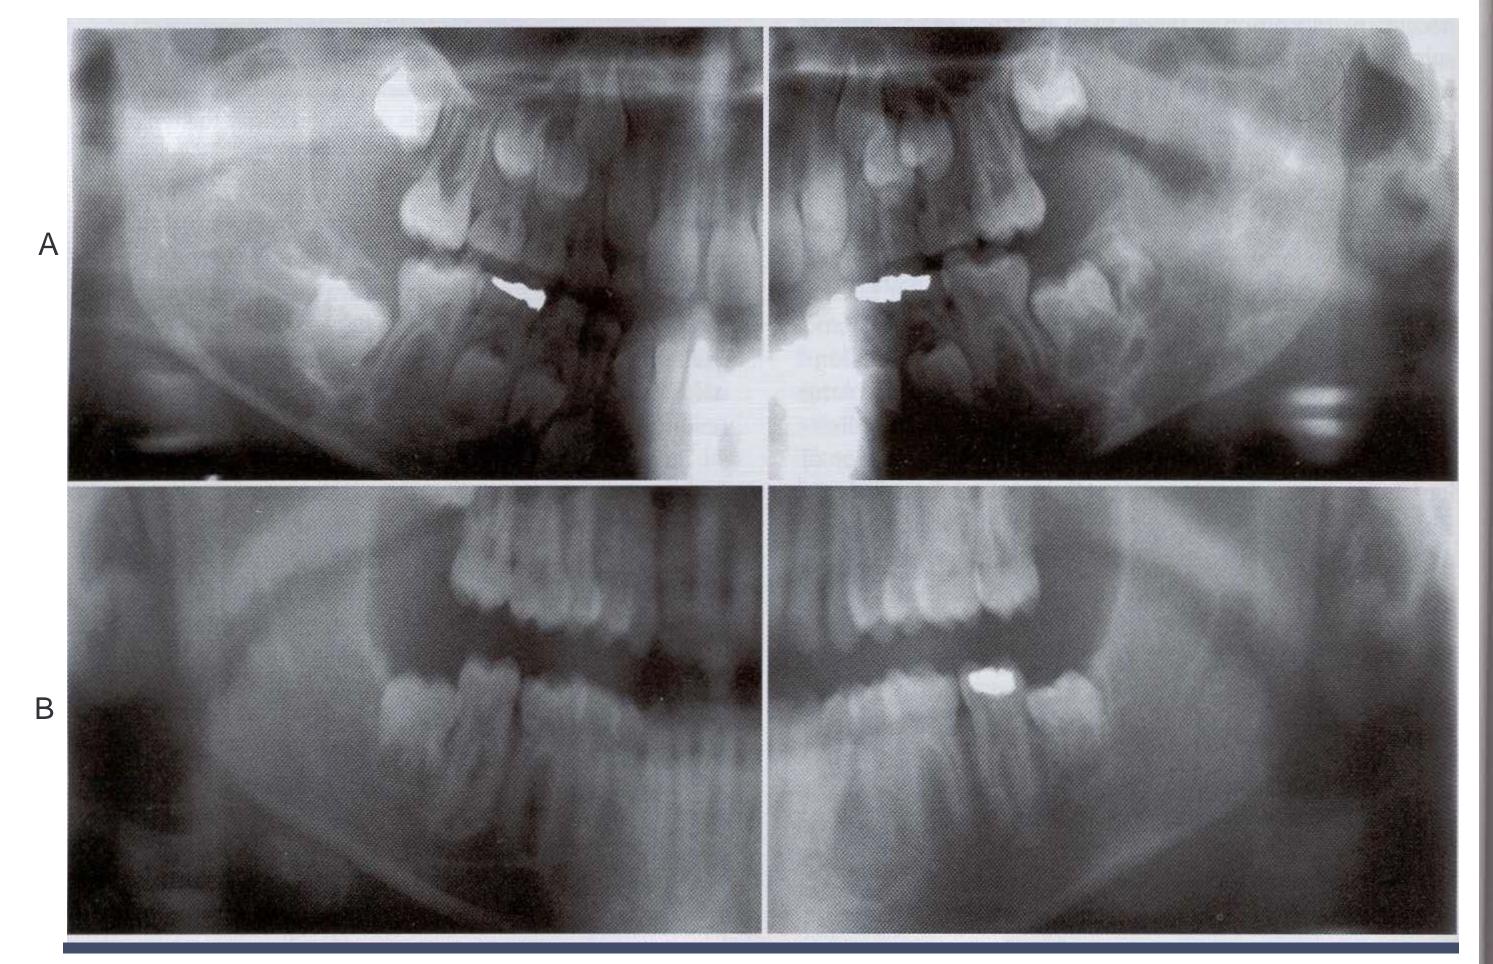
• Cherubi sm. A, Panoramic radiograph of a 7-year-old white male. Bilateral multilocular radiolucencies can be seen in the posterior mandible. B, Same patient 6 years later. The lesions in the mandibular rami demonstrate significant resolution, but areas of involvement are still present in the body of the mandible. (Courtesy of Dr. John R. Cramer.)
